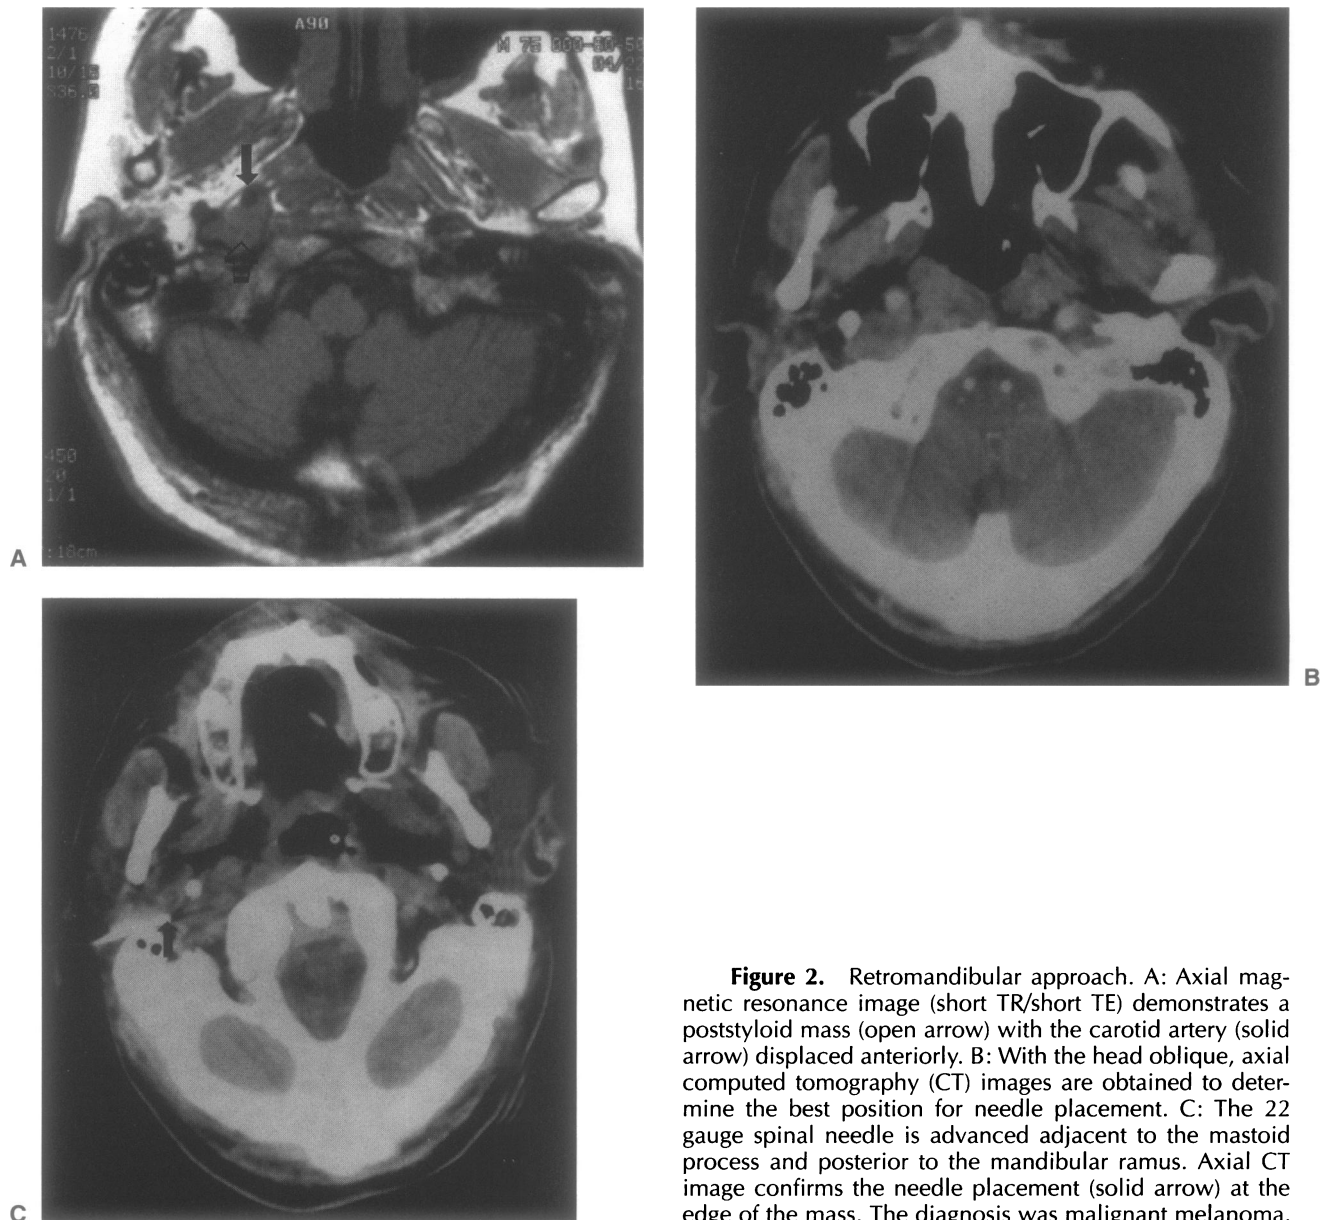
Retromandibular approach. A: Axial magnetic resonance image (short TR/short TE) demonstrates a poststyloid mass (open arrow) with the carotid artery (solid arrow) displaced anteriorly. B: With the head oblique, axial computed tomography (CT) images are obtained to determine the best position for needle placement. C: The 22 gauge spinal needle is advanced adjacent to the mastoid process and posterior to the mandibular ramus. Axial CT image confirms the needle placement (solid arrow) at the edge of the mass. The diagnosis was malignant melanoma.
